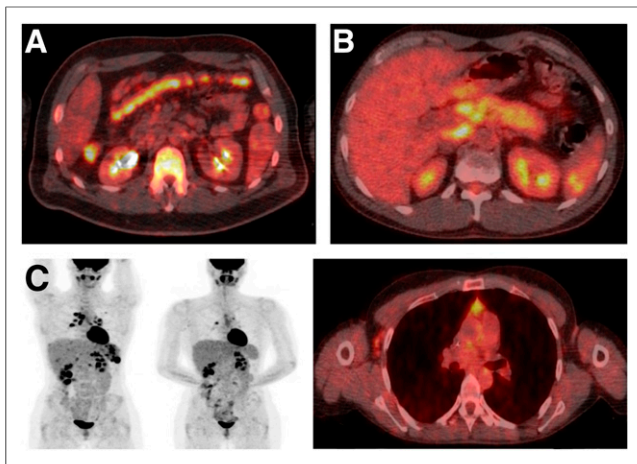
New non-Hodgkin lesions appeared during anti-PD1 treatment. ^{18}F -FDG PET/CT detected grade 2 colitis (A), pancreatitis (B), and zona activation in right axilla (C, from left to right: maximum-intensity-projection baseline, maximum-intensity-projection and fused PET/CT image during follow-up).
